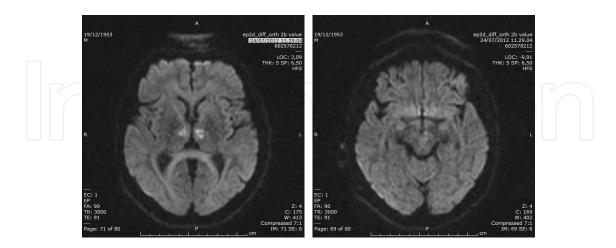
Brain MRI scan (DWI sequences) of a 59 years old man presenting with an acute onset of confusion, ideative and motor slowness and apathy with memory loss. A marked cognitive and motor slowness and apathy remained after 15 days from onset. MRI scan showed ischemic lesions in the medial part of both thalami and in the midbrain (top of the basilar syndrome).
